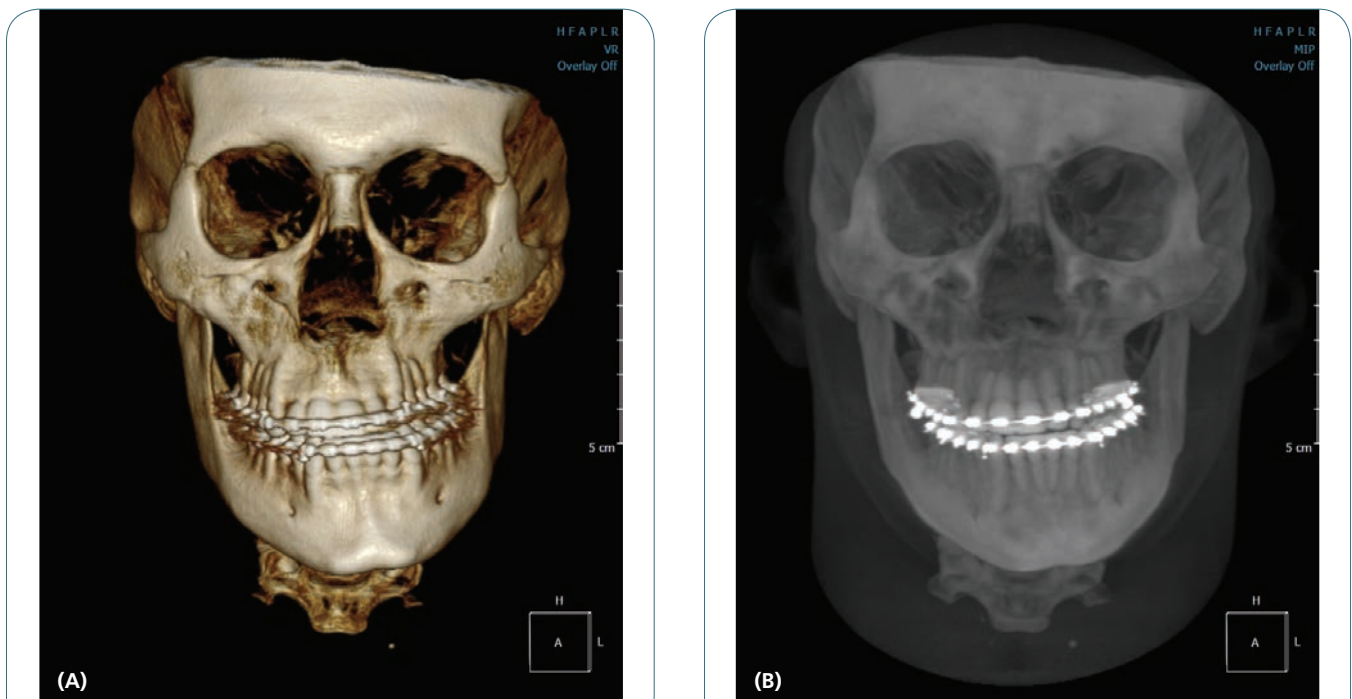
Using enhanced technologies the oral surgeon has various types of views to show the before and after treatment of an orofacial trauma patient: (A) Front view showing the trauma that shifted the mandible. (B) X-ray view of the skull.
